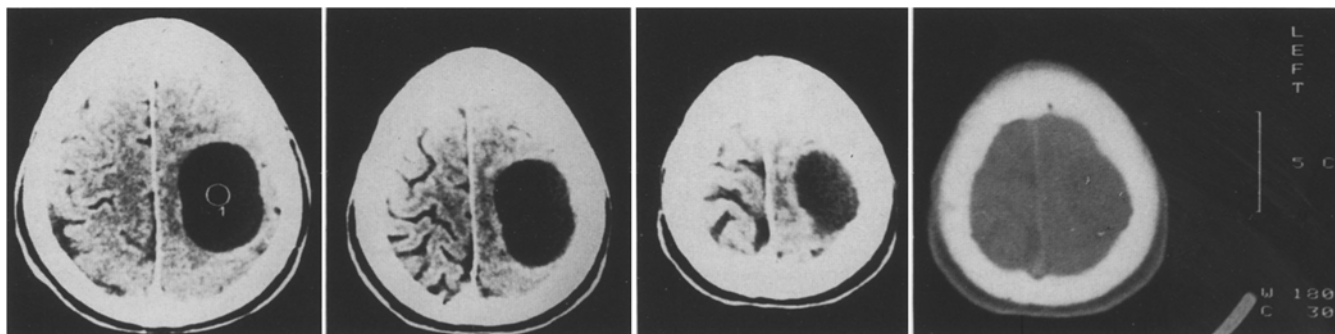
A surgically verified leptomenigeal cyst in the left parietal lobe. Although the narrowing of the internal table is obvious in the axial CT scans, coronal sections are necessary to show the defect in the cranium in order to make precise differential diagnosis
